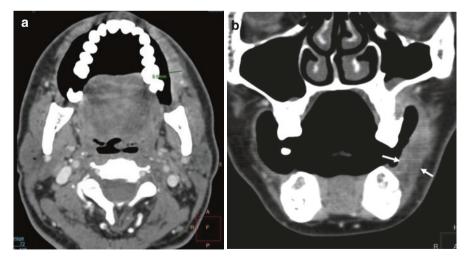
(a, b, c) CT images of a patient with an extensive malignant lesion of the right check, the lip demonstrating transmural spread and dermal involvement (*star*). There is fistulation anteriorly and thickening and infiltration of the platysma (*solid arrow*). Coronal projection shows the extent of the lesion, involving the superior and inferior GBS
